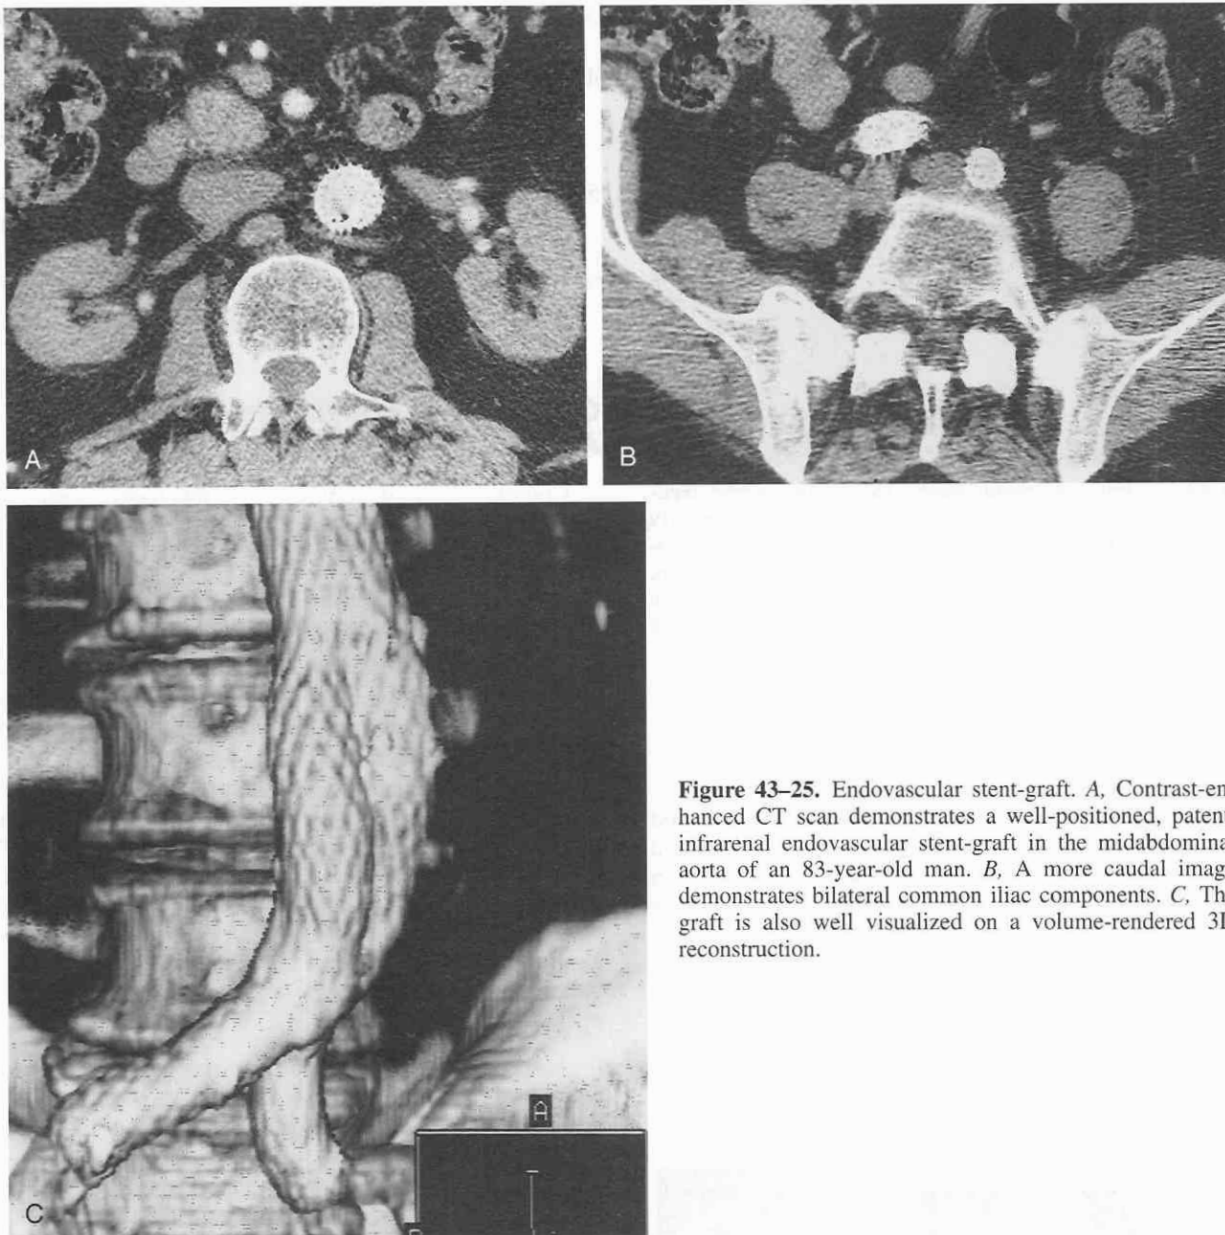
Endovascular stent-graft. *A*, Contrast-enhanced CT scan demonstrates a well-positioned, patent, infrarenal endovascular stent-graft in the midabdominal aorta of an 83-year-old man. *B*, A more caudal image demonstrates bilateral common iliac components. *C*, The graft is also well visualized on a volume-rendered 3D reconstruction.
